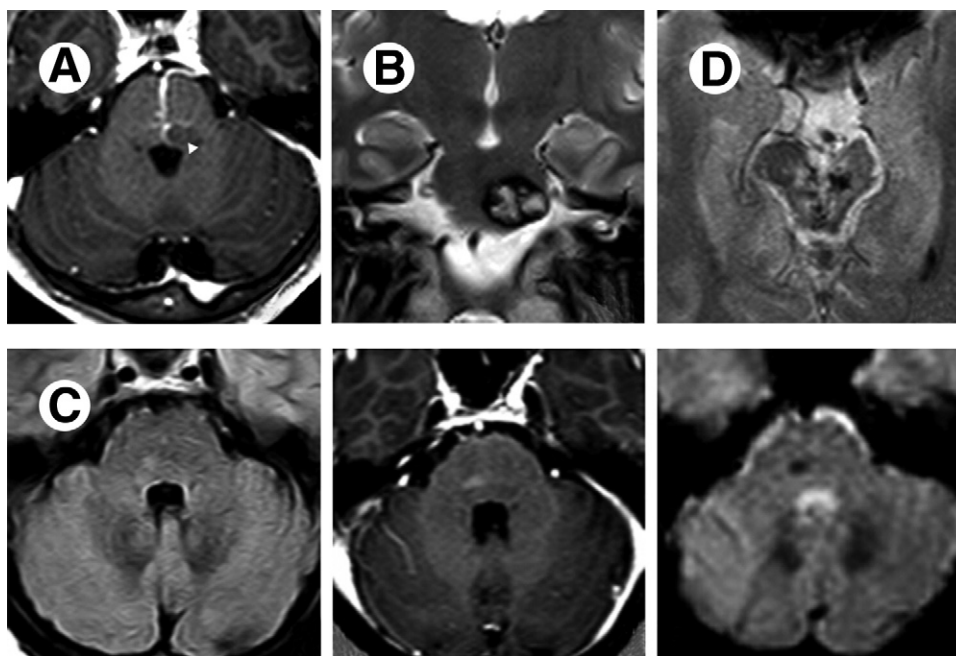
(A) Venous angioma and cavernous malformation. Axial gadolinium-enhanced 3D FFE-T1 shows stellate, tubular vessels (caput medusae/“Medusa’s head”) from the fourth ventricle floor converging on a dilated left pontine collector vein draining into the dural sinus. Coexisting cavernous malformation is frequent as shown (arrowhead). (B) Cavernous malformation. Coronal turbo spin echo (TSE) T2 shows a reticulated “popcorn-like” lesion in the left hemipons with a mixed signal core and hypointense hemosiderin rim. (C) Capillary telangiectasia. Axial FLAIR (left) shows stippled foci of hyperintensity in the right pons. Axial gadolinium T1-weighted image (middle) demonstrates faint stippled enhancement of the lesion. Axial DWI (FFE-EPI T2*) (right) reveals a poorly defined hypointense lesion. (D) Arteriovenous malformation. Axial FFE-T2 shows a “honeycomb” of multiple flow voids in the mesencephalic region typical of arteriovenous malformation and a surrounding high signal due to gliosis. Note marked midbrain atrophy.
